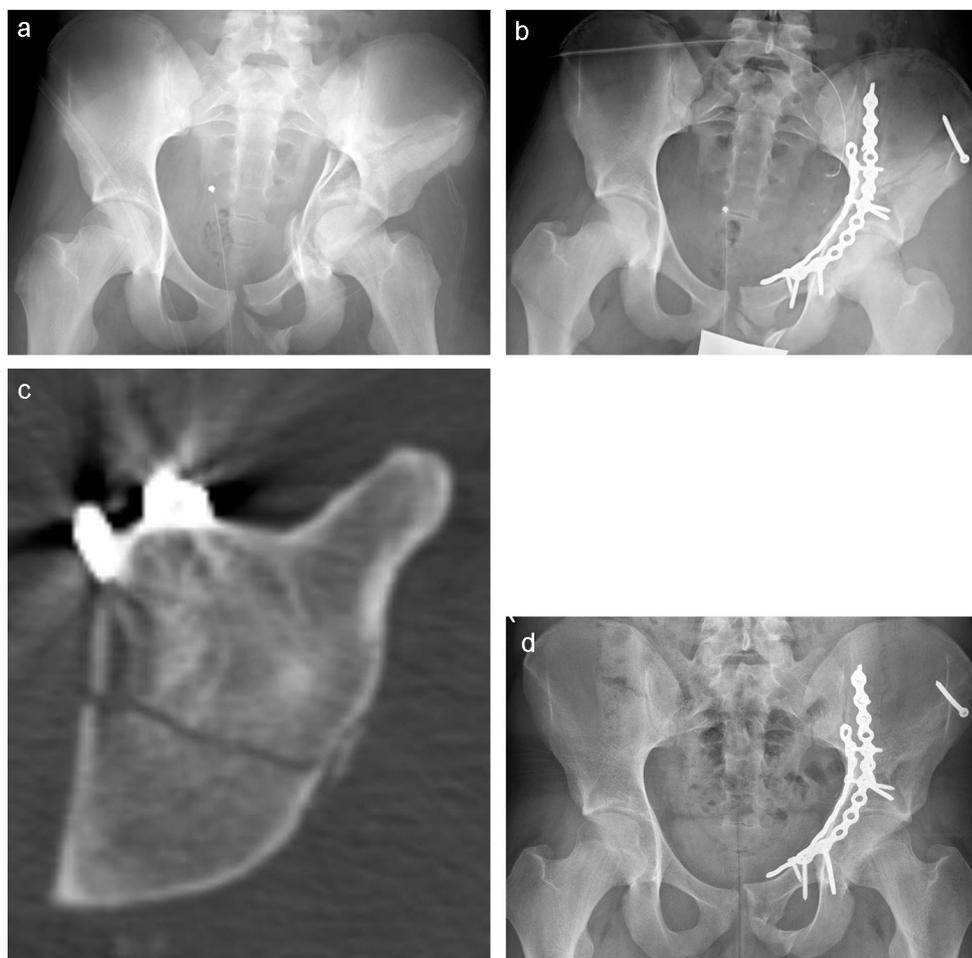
(a) Anteroposterior radiograph of a 16-year-old patient who sustained a both column acetabular fracture due to a skiing accident. The pre-operative image is shown. (b) Anteroposterior radiograph presenting the postoperative image with no residual displacement after fracture reduction and fixation. (c) Postoperative axial CT scan at the level of the acetabular dome presenting anatomic reduction, with a gap of 1–2 mm. (d) Anteroposterior radiograph 2.5 years after surgery. No signs of posttraumatic osteoarthritis are observed, the radiological status at the latest follow-up was scored as “excellent” according to the Matta criteria.
